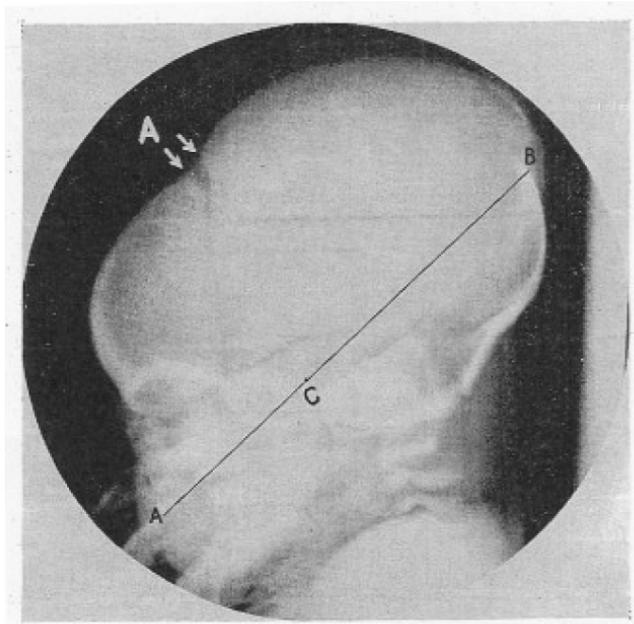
Lateral radiograph of a newborn after vaginal delivery. There is elongation of the maxillovertical diameter AB, with overlap and elevation of the parietal bones at the anterior fontanelle (large A) and posterior fontanelle (B). (Reproduced from Moly¹²⁹)
